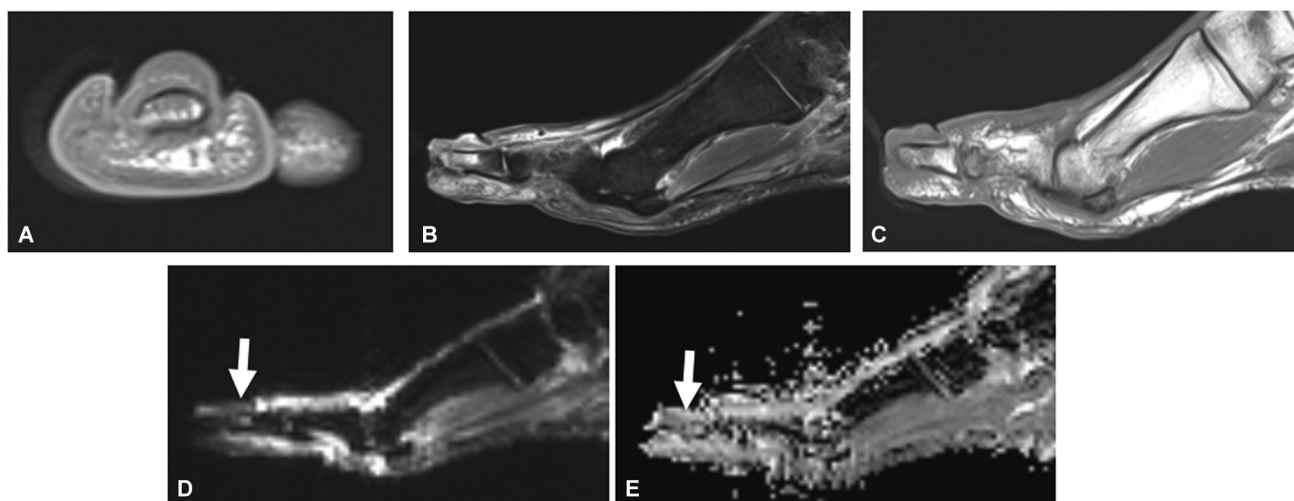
Patient with proven osteomyelitis of the first distal phalanx. (A) Axial T1-weighted (T1W), (B) sagittal short tau inversion recovery (STIR), and (C) T1W images of the first distal phalanx lacking the “ghost sign.” Corresponding (D) sagittal diffusion-weighted imaging (DWI) and (E) apparent diffusion coefficient (ADC) map of the first distal phalanx showing the “ghost sign” (arrows).
